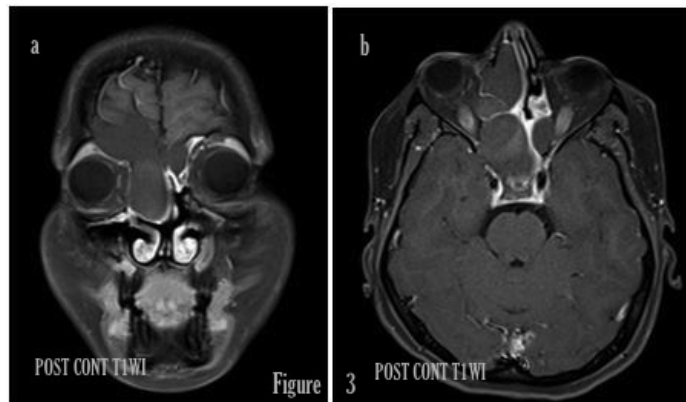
(a) and (b) Post contrast MRI shows minimal enhancement in the polyp.
